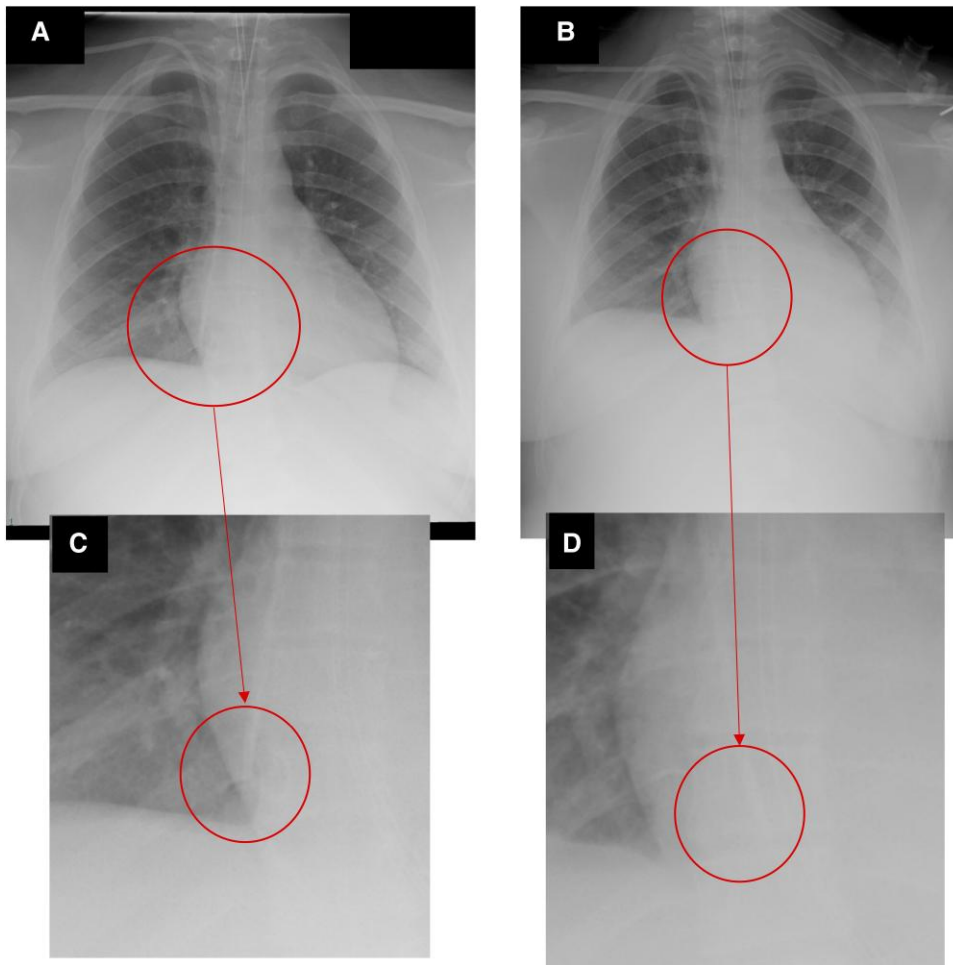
(A and C) Chest X-ray of the patient performed the morning before the diagnosis of cardiac tamponade. Notably, the tip of the central venous catheter points to the free wall of the right atrium. (B and D) Chest X-ray of the patient performed after retraction of the central venous catheter.
